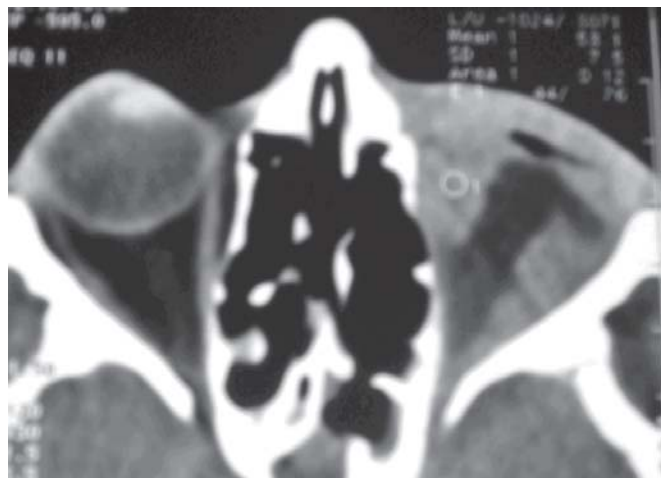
Axial CT scan picture of patient after enucleation
